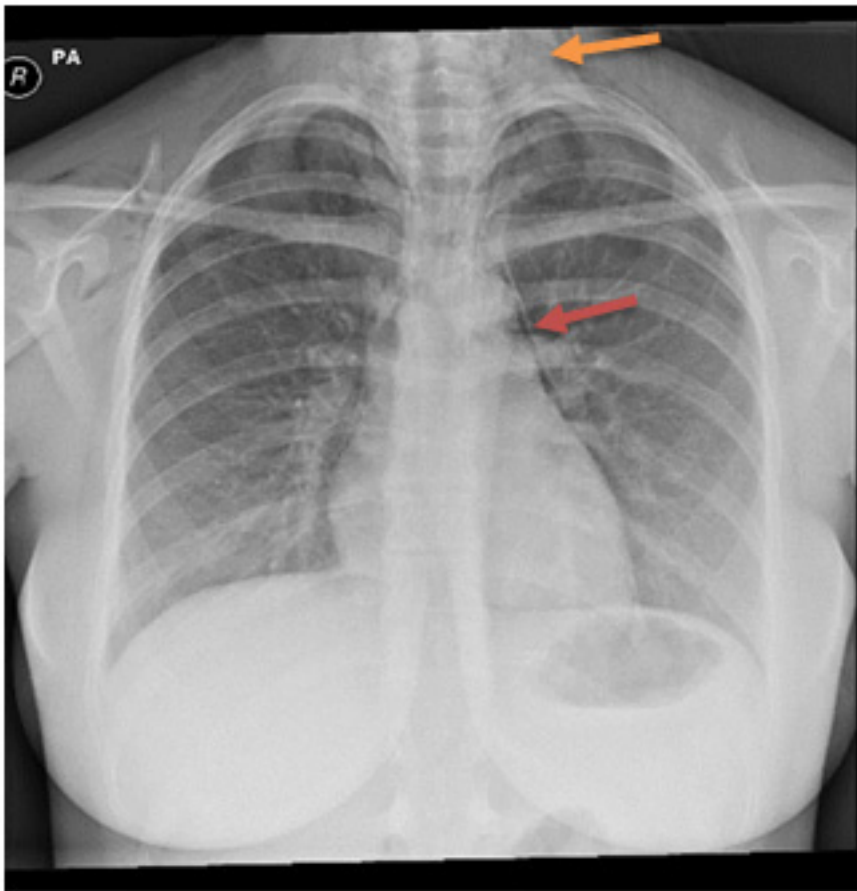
CT thorax coronal view showing pneumomediastinum as shown by the red arrow and subcutaneous emphysema indicated by the yellow arrow.
